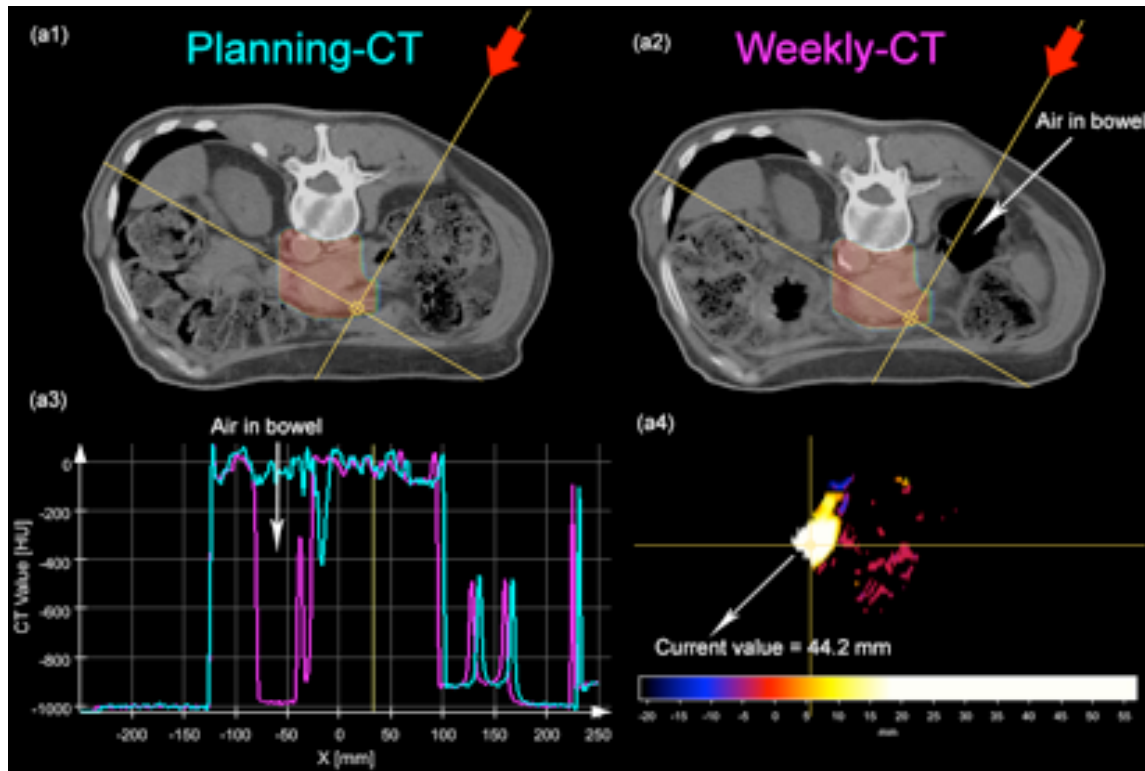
Evaluation of the accWEPL for the patient H11 for the CT_1 (a2) comparatively with the CT_{plan} (a1) for the oblique posterior right field. (a3) shows the difference in the CT value for a profile drawn along the beam path. This difference will be translated in accWEPL changes as the pointed to in image a4). The yellow axis in image a4) can be moved along the $\Delta accWEPL$ in order to measure its current value. Moreover, this axis is synchronously moved in the CT of the patient (a1 and a2) and the unidimensional profile (a3) to help in the interpretation of the results. As example of this evaluation method the axis was in this figure placed after a region of large density variations, i.e. air in the bowel compared to the planning CT.
